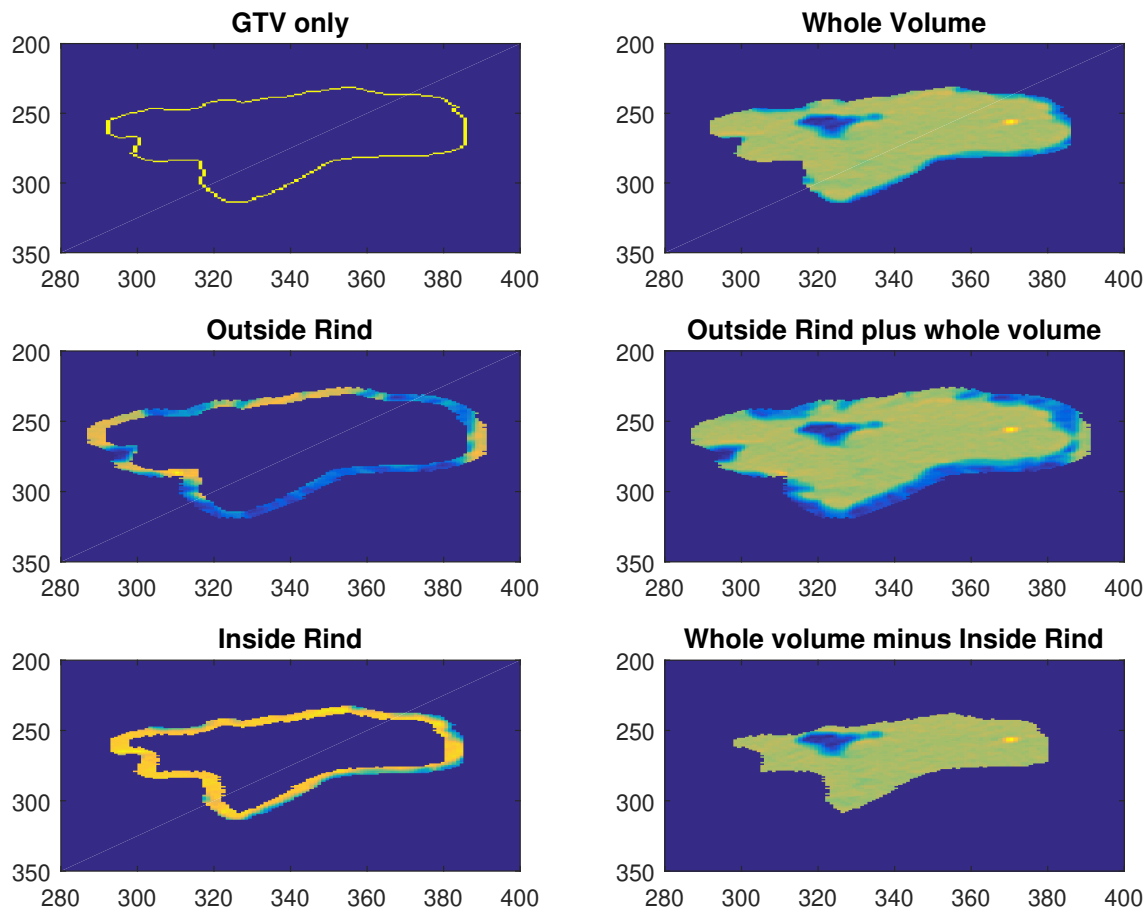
Example outside rind compared to inside rind and whole tumour volume for a single CT slice.
